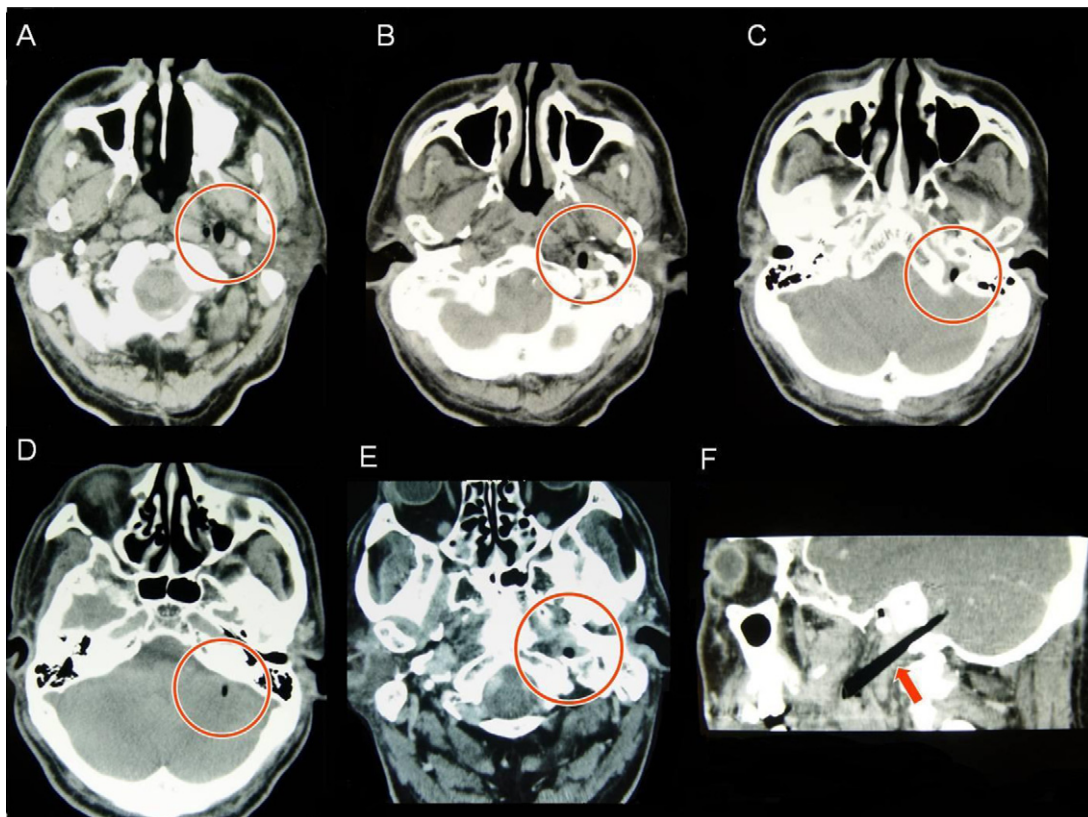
Computed tomography images. (A–D) Plain CT axial images showing the foreign body as a round low-density area (inside red circle), penetrating the soft palate and passing through the jugular foramen to the cerebellum. (E and F) CT angiography images showing no active bleeding or hematoma. (E) Sagittal view enhanced CT showing the jugular foramen clearly. (F) Sagittal view enhanced CT showing the foreign body clearly.
